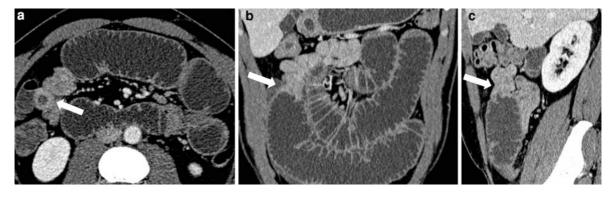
Contrast-enhanced axial (a), coronal (b) and sagittal (c) CT scan of the abdomen show a stenosing lesion (*arrow*) of distal mall bowel loop with severe and diffuse dilation of proximal small bowel loops due to the presence of small bowel adenocarcinoma
